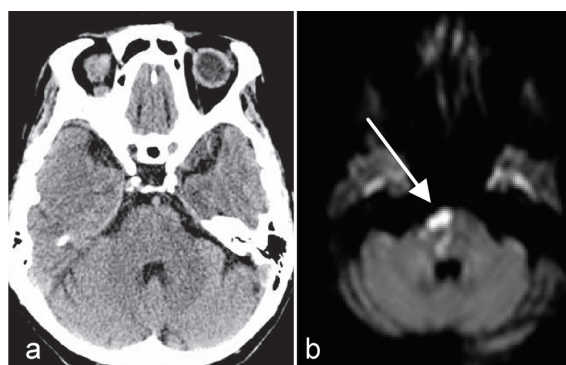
An 82-year-old woman with acute infarction. a) NCCT scan is unremarkable. b) DWI image shows small lesion at the right-sided of pons with restricted water diffusion shown as bright signal intensity on DWI (arrow) and low signal intensity in ADC image (not shown).
